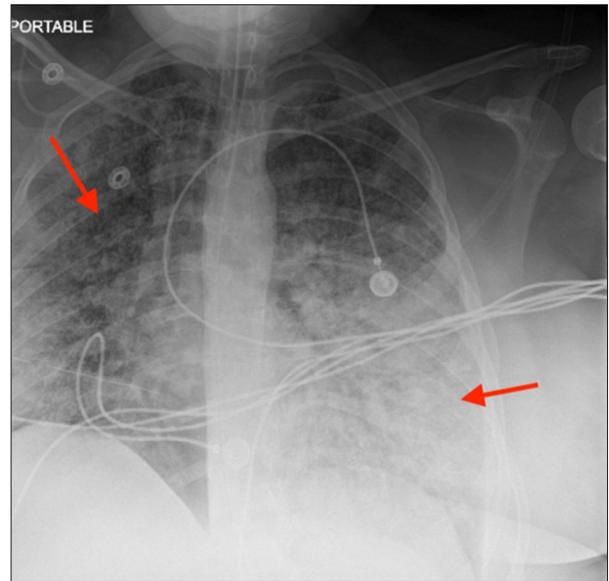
Chest X-ray on postoperative day 15 shows a worsening course with increased confluent opacities (arrows).
